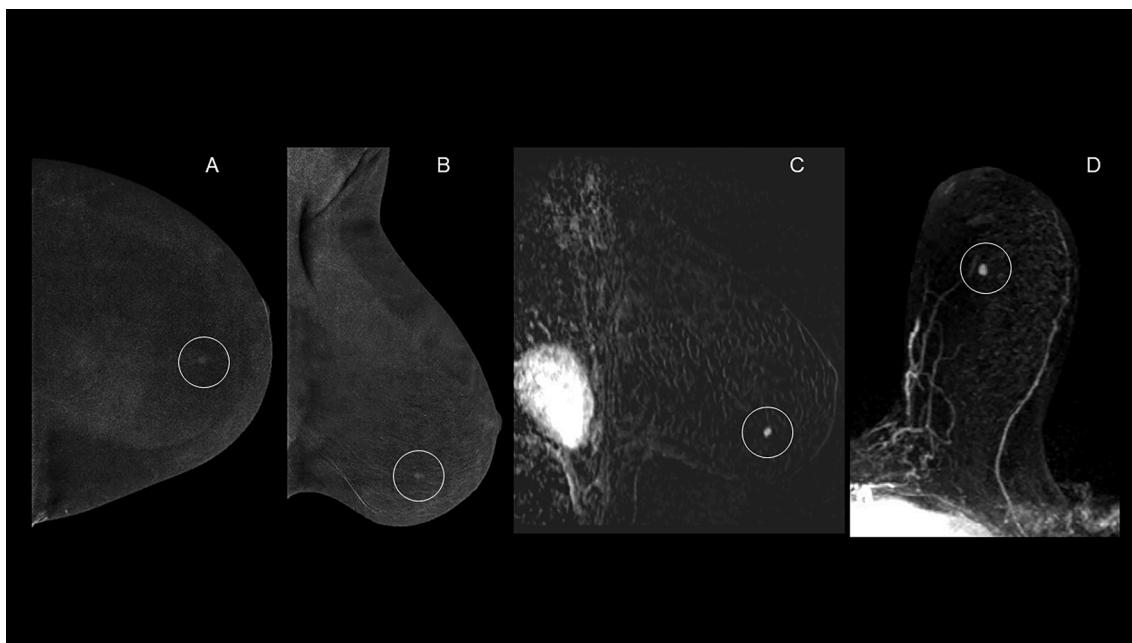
64-year-old with family history of breast cancer. Recombined left craniocaudal (A) and mediolateral oblique (B) views show a 0.5 cm enhancing mass in the lower inner quadrant. No corresponding abnormality was identified on low-energy images or targeted ultrasound. Magnetic resonance imaging sagittal (C) and maximum intensity projection (D) image show a corresponding 0.5 cm enhancing mass in the 7:00 axis. Magnetic resonance imaging-guided biopsy yielded invasive ductal carcinoma.
